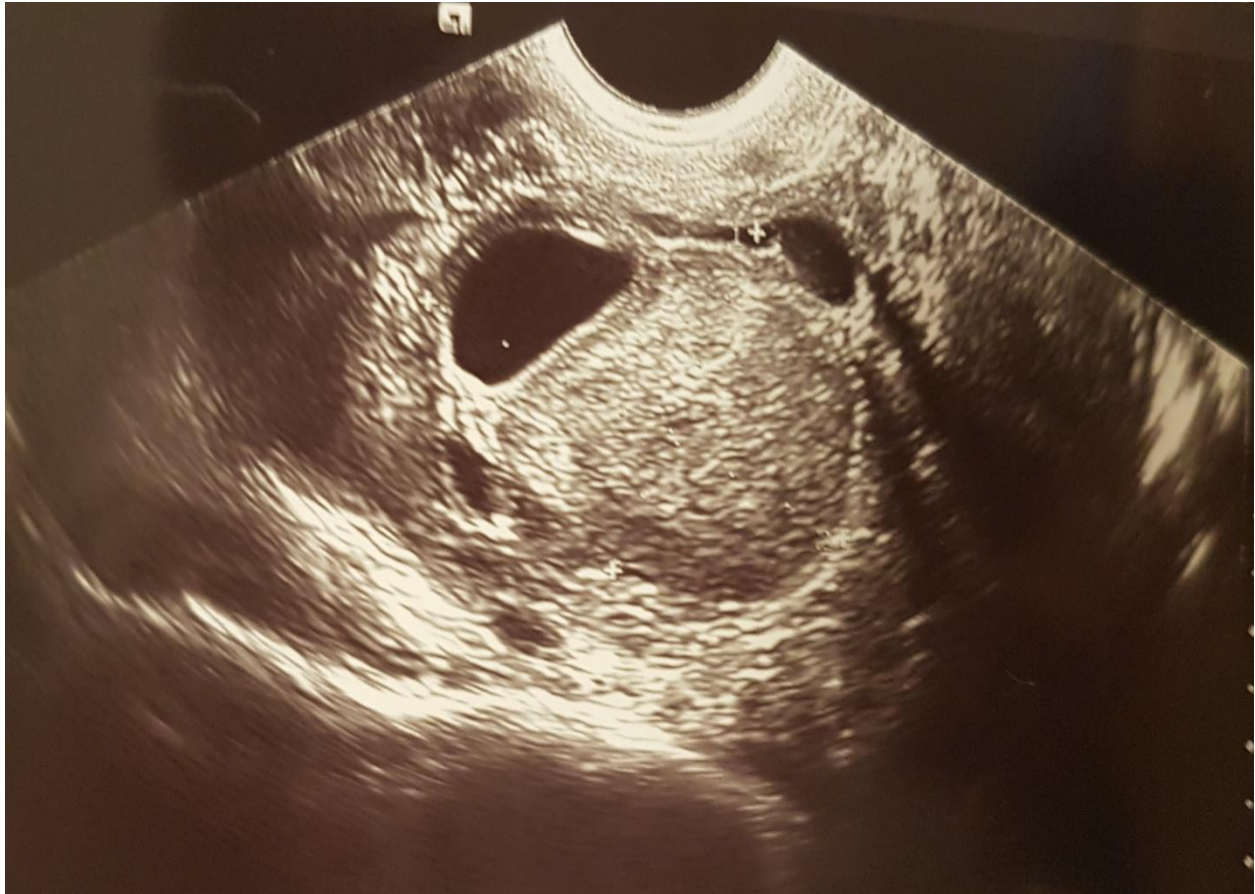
Transvaginal sonography.
